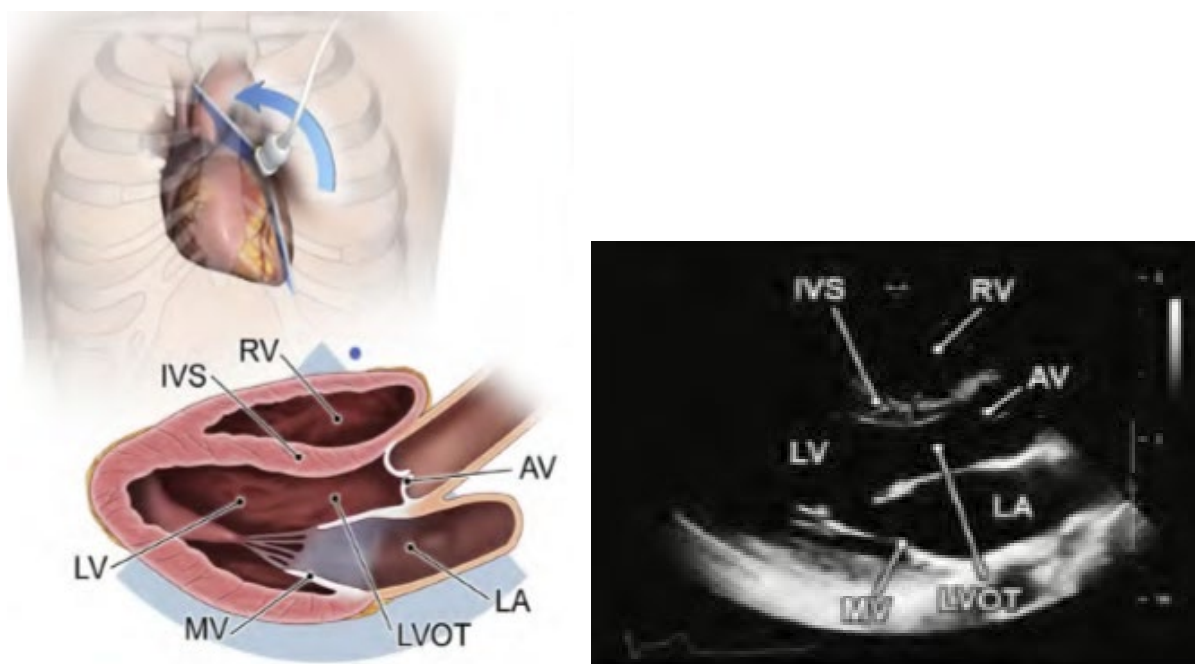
Parasternal long axis view. Reproduced with permission from the American Society of Echocardiography. (135)
